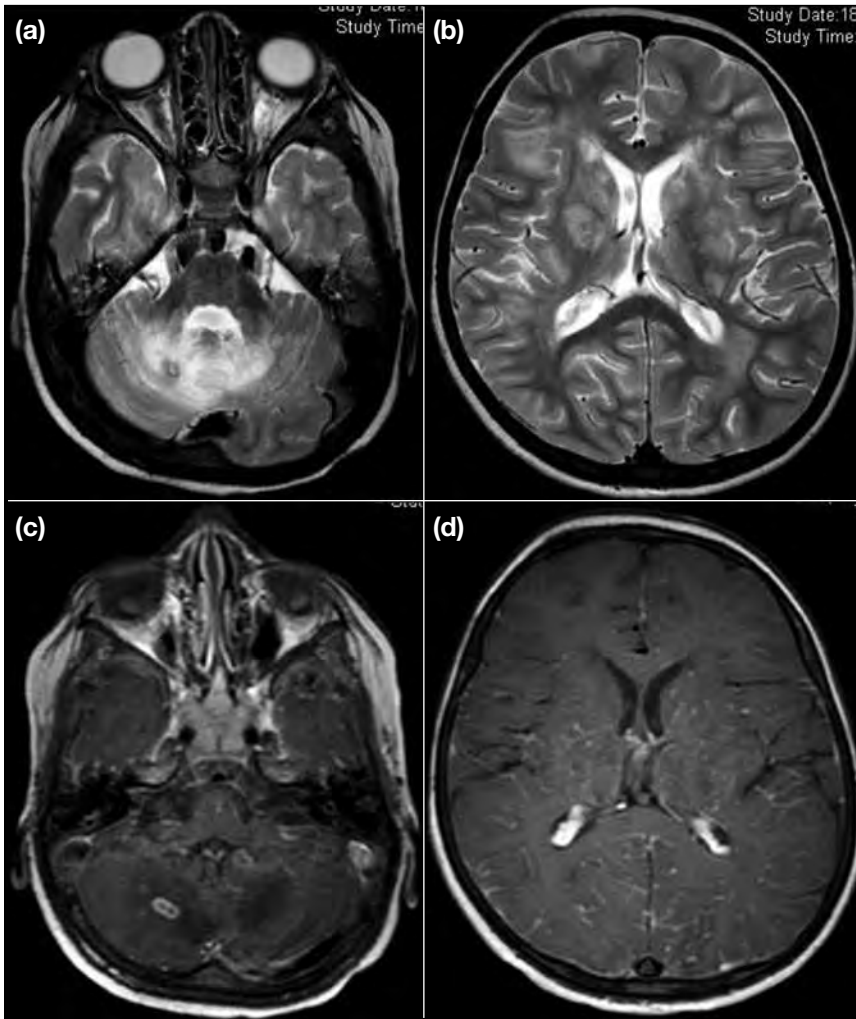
Patient 2. Magnetic resonance imaging scans showing (a, b) high-intensity T2 signal at bilateral cerebral and cerebellar white matter, bilateral deep grey nuclei and brainstem; (c) right cerebellar rim-enhancing lesion; and (d) diffuse leptomeningeal enhancement affecting both supra- and infra-tentorial regions.
